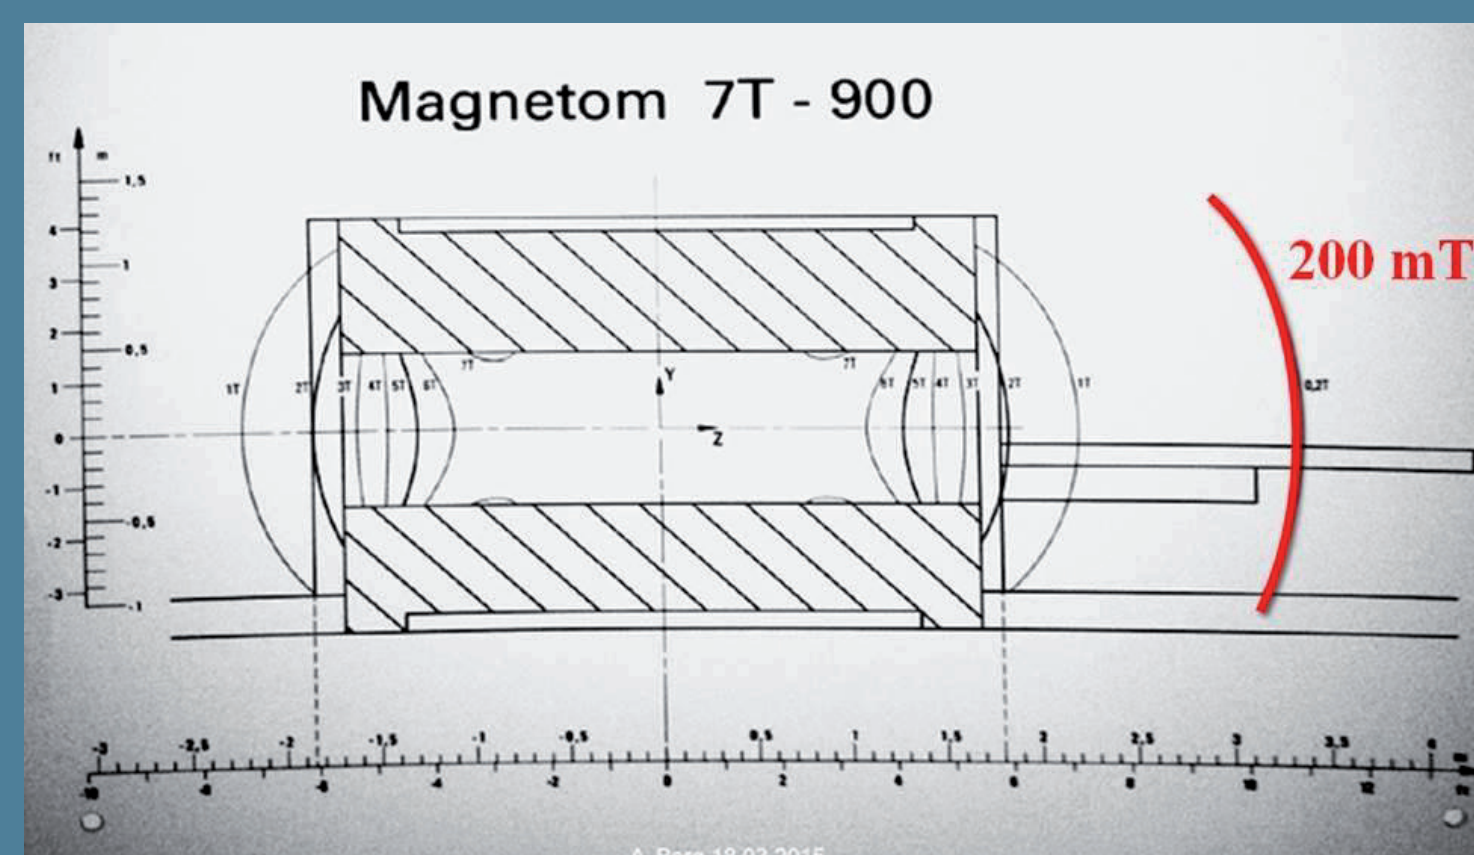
Fringe field of the high field human 7 T MRI-scanner (sagittal section)
